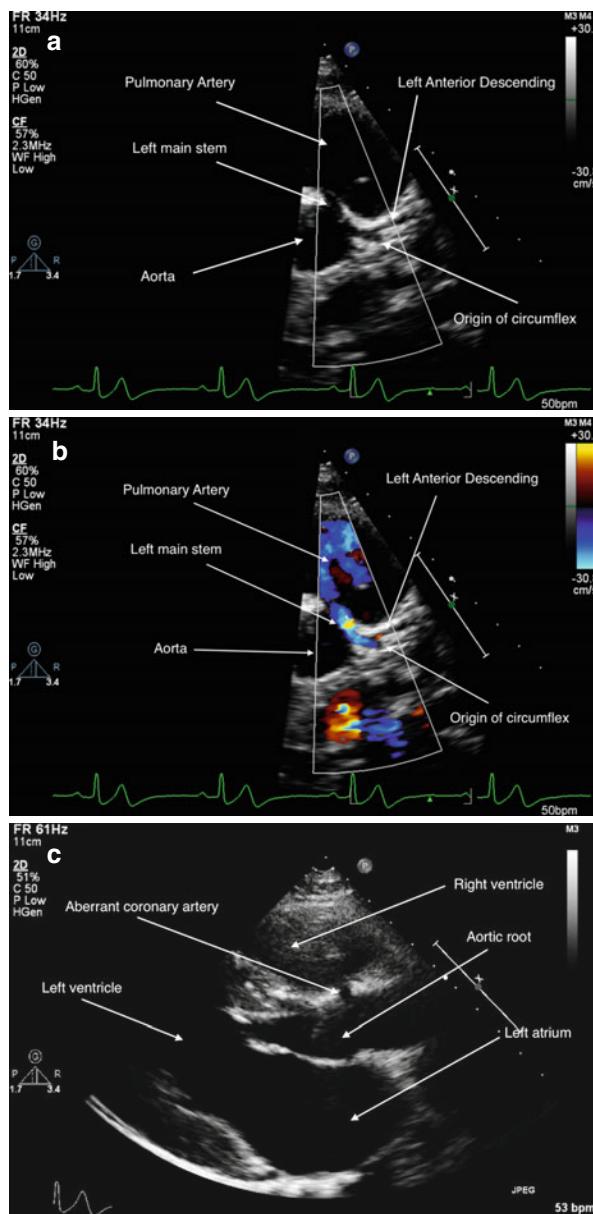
(a) Echocardiographic 2D image of left coronary artery demonstrating interarterial segment of LCA followed by normal bifurcation. (b) Colour flow image of LCA demonstrating interarterial segment. (c) 2D image in the parasternal long axis showing the aberrant coronary artery
